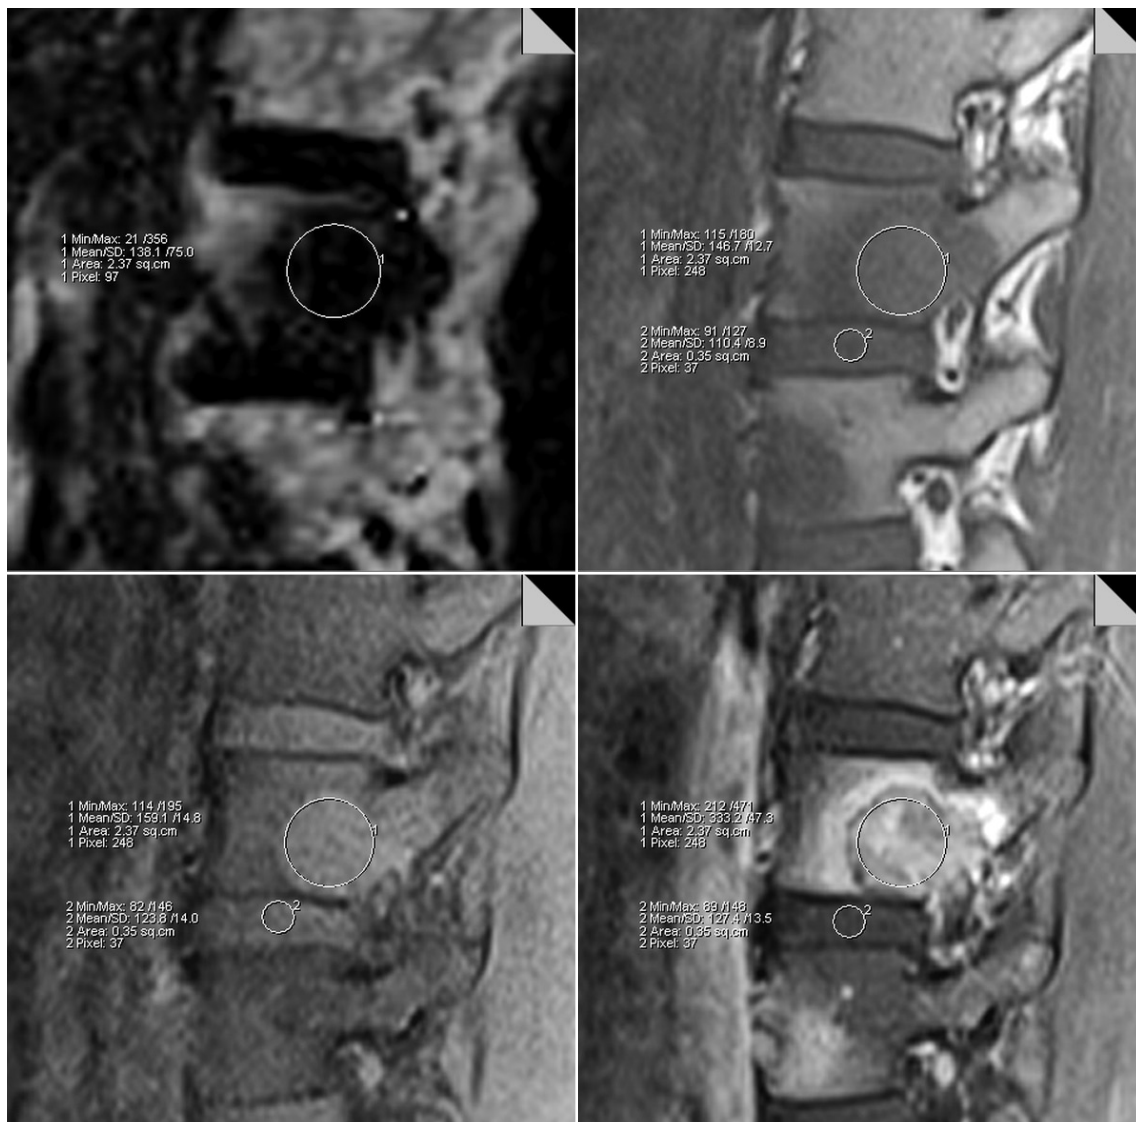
Region of interest (ROI) placement and parameter measurement. Screen-captured image during ROI placement for parameter measurement of lesion and disc on workstation is shown. Images used for analysis were from fat-signal fraction (FF) mapping image from three-point Dixon volume interpolated breath-hold gradient-echo sequence (top left), T1-weighted imaging (T1WI, top right), and pre- (bottom left) and post- (bottom right) gadolinium (Gd)-enhanced fat suppressed (FS) T1WI. Details regarding ROI placement are described in text. FF was obtained from FF mapping sequence image by directly placing ROI. Lesion-disc ratio (LDR) was obtained from image of T1WI. Contrast-enhancement ratio (CER) was obtained from images of pre- and post-Gd-enhanced FS T1WI. Calculations for these parameters are described in text. Images of this capture were obtained from representative metastatic lesion from gastric cancer in 57-year-old man. FF, LDR, and CER were 9.8%, 92.1%, and 157.6%, respectively. All parameters indicated that lesion was malignant.
